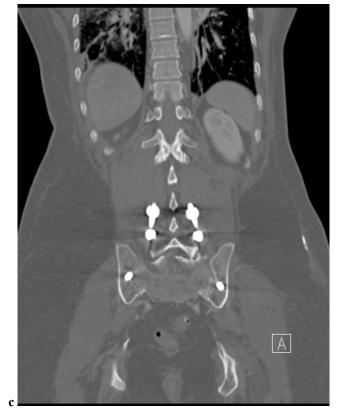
CT scan of the pelvis demonstrating appropriate screw placement between the cortical walls of the ilium.
